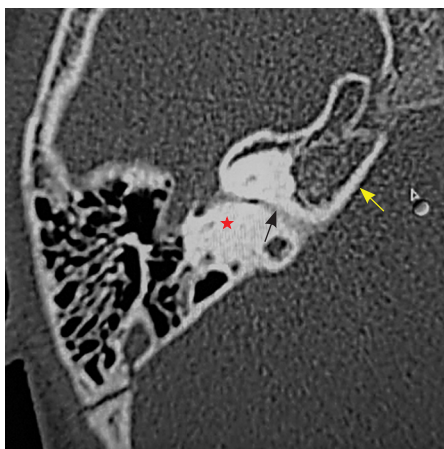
HRCT temporal bone, axial section bone window shows CLA with otic capsule (red star, otic capsule; yellow arrow, petrous bone; black arrow, facial nerve).
